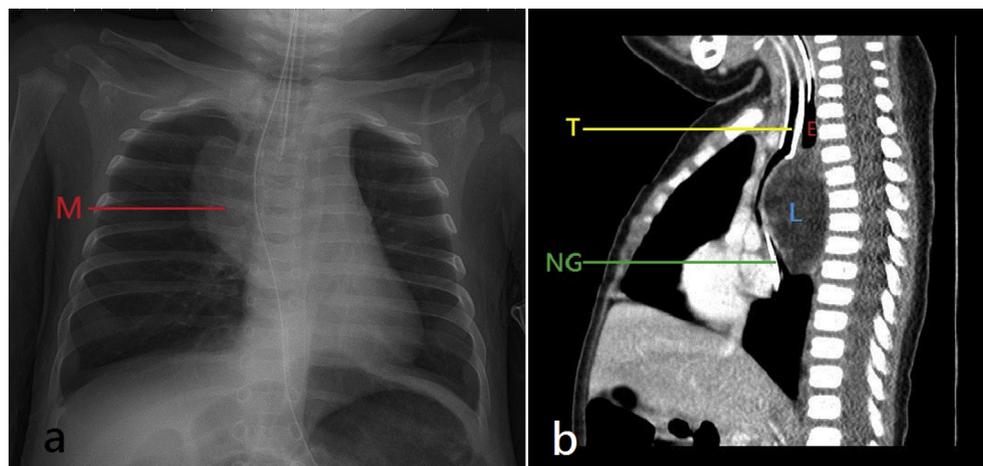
Images: a Chest radiograph (anterior–posterior view): A huge mediastinal mass lies over the heart (arrow). b Computed tomography: A fatty mass 6.3 × 4.7 × 3.7 cm in dimensions protruding from the upper posterior mediastinum has displaced the trachea, the bronchus, and the esophagus anteriorly (E: esophagus, T: trachea with an endotracheal tube, L: lipoblastoma, NG: nasogastric tube).
